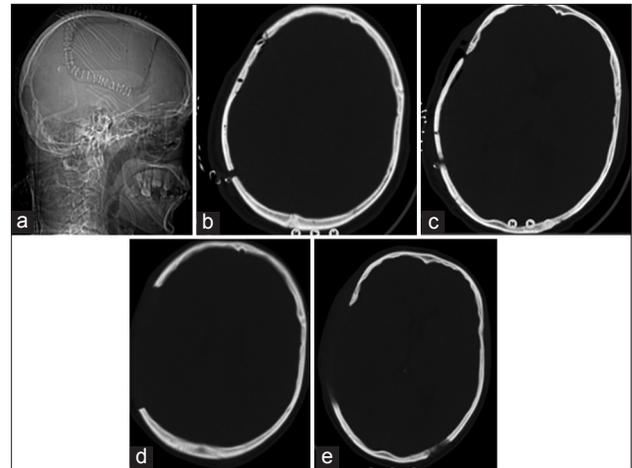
(a-e) Post-operative axial plan cranial computed tomography showing late cranioplasty operation (6 months after the first subdural and the second epidural hematomas intervention), we fix up the bone graft which was embedded subcutaneously in the right lower quadrant of the abdomen
